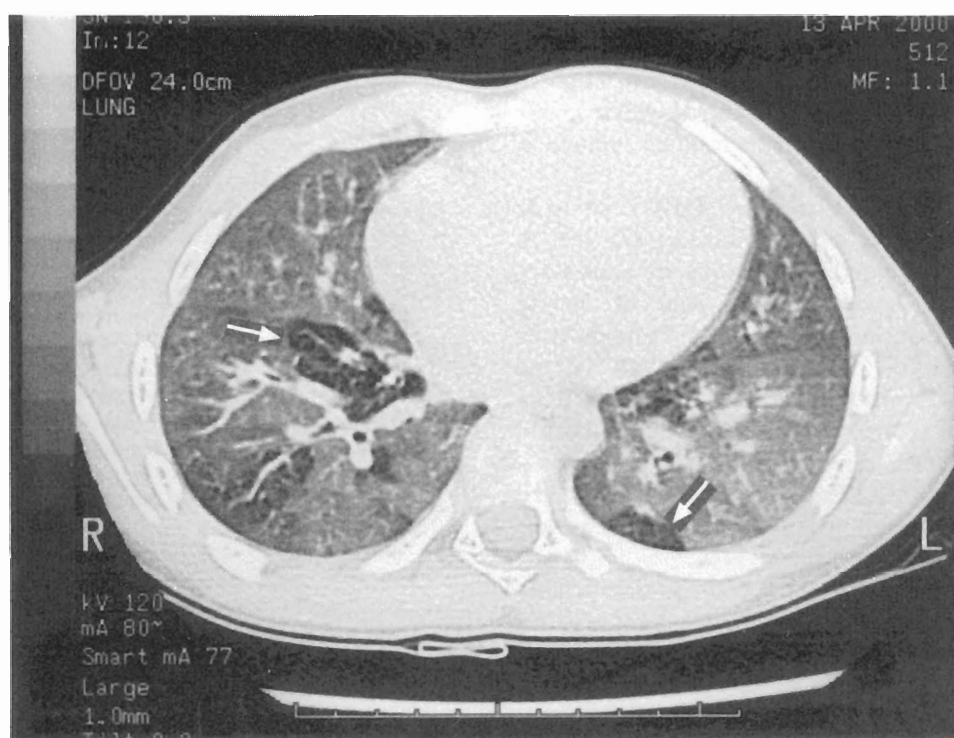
(a, b) HRCT scan through the lung basis of a 17-year-old patient in inspiration (a) and in expiration (b) demonstrating mosaic perfusion in both lower lobes during expiration only (b, arrows). In addition, there are bronchiectasis, mucous plugging and consolidation.
